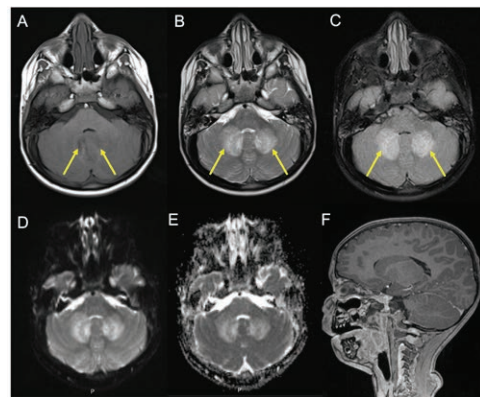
Cerebral MRI revealing the presence of hypointense lesions on axial T1-weighted images (A, arrows) and hyperintense on axial T2-weighted (B, arrows) and FLAIR (C, arrows), centered on the dentate nuclei of the cerebellum and involving the adjacent white matter. The lesions are relatively symmetrical and do not exhibit diffusion restriction (D, E) nor do they enhance after gadolinium administration on T1-weighted imaging (sagittal plane, F).
